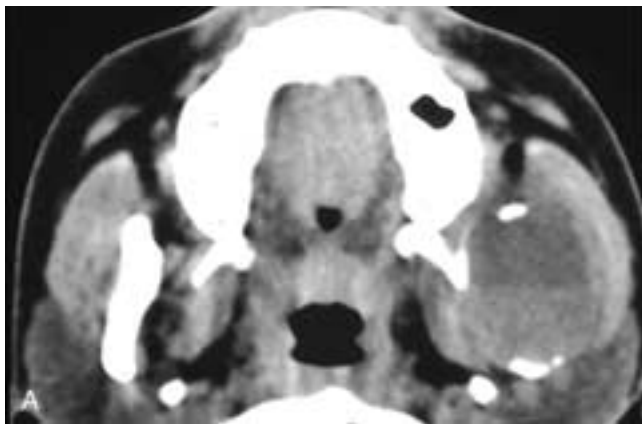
Axial CT scan (A) shows an expansile cyst arising in the left mandibular ramus. Only a small region of cortex remains along the anterior and posterior edges of the ramus. The masticator space muscles are displaced away from the ramus but are otherwise normal. There is a fluid-fluid level in this benign bone cyst with hemorrhage. Axial CT scan (B) shows an area of cystic expansion of the right posterior body of the mandible, with erosion of the cortex around the mass. The masticator muscles are poorly seen as they are stretched around the lesion. This was a rare metastatic meningioma.
